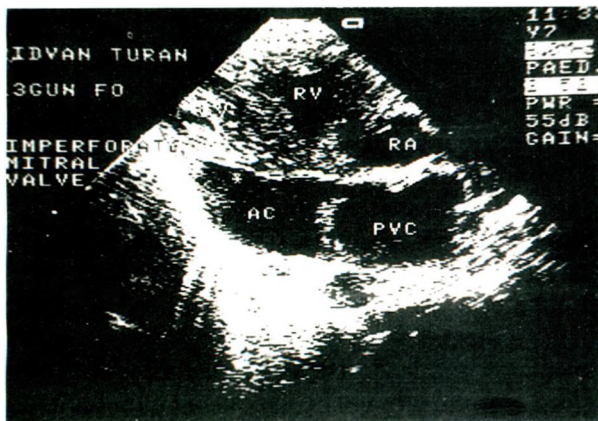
Parasternal long axis view showing the membrane in the place of mitral valve between pulmonary venous chamber and atrialized chamber.
